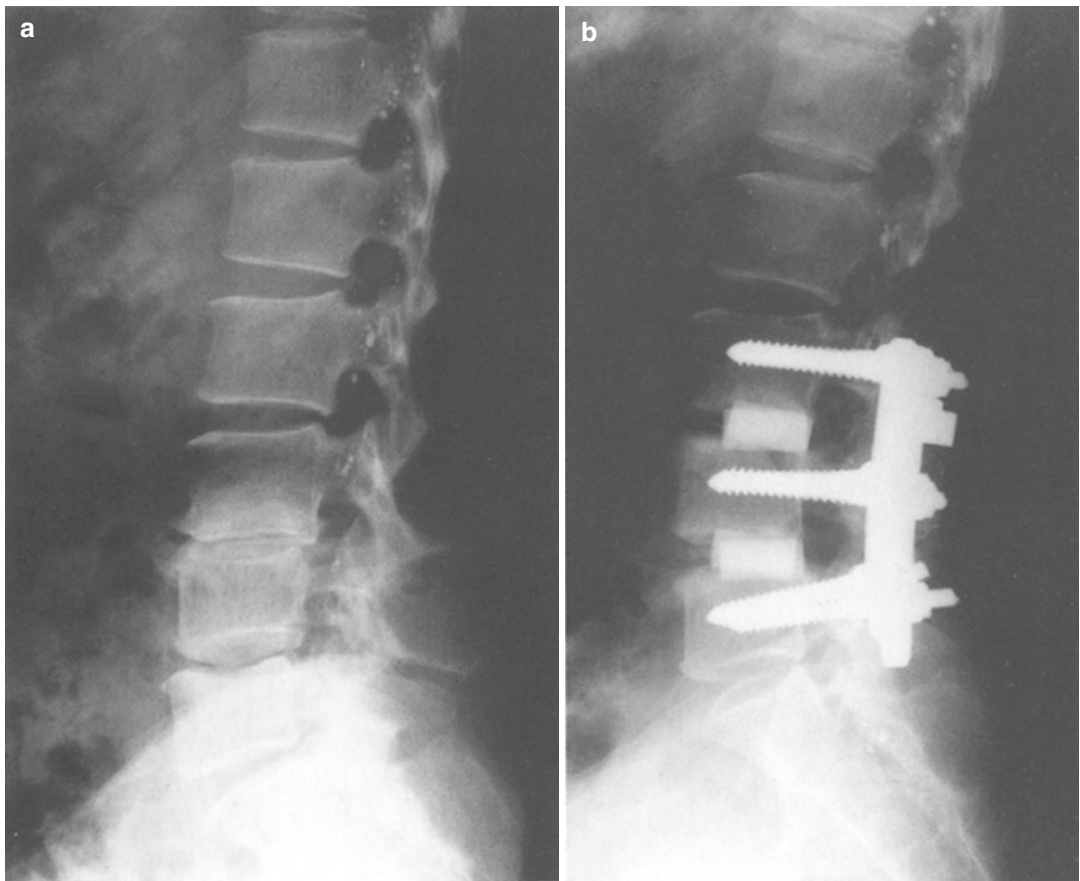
(a) A case of multiple degenerative spondylosis of the lumbar spine developed in a 58 year old female. (b) A postoperative X-ray picture showing the results of postero-lateral interbody fusion using intervertebral spacers made of AW-GC
